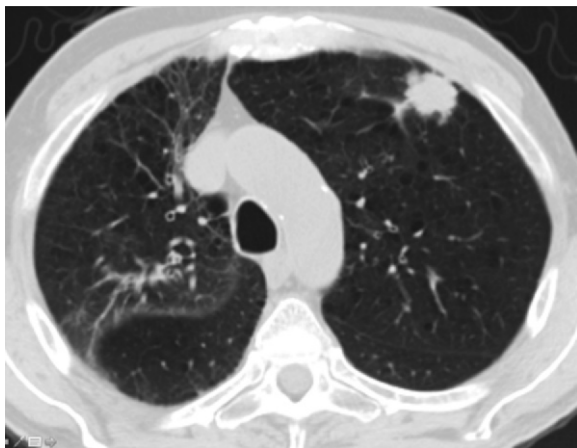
Adenocarcinoma in a 52-year-old man with HIV infection who was receiving ART. The patient presented with dyspnea and had a CD4 count of 287 cells/ μ L. CT image shows mild emphysema and an irregular peripheral nodule in the left upper lobe. Biopsy demonstrated lung adenocarcinoma.
